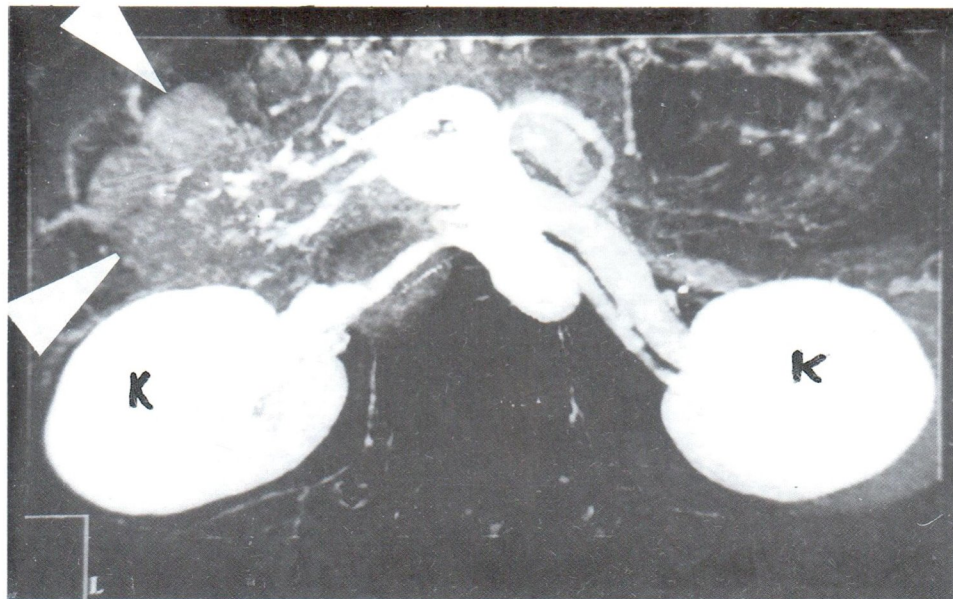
Spiral CT angiography showed that the mass was hypovascular. Branches of the renal veins and arteries were seen in the periphery of the mass.
